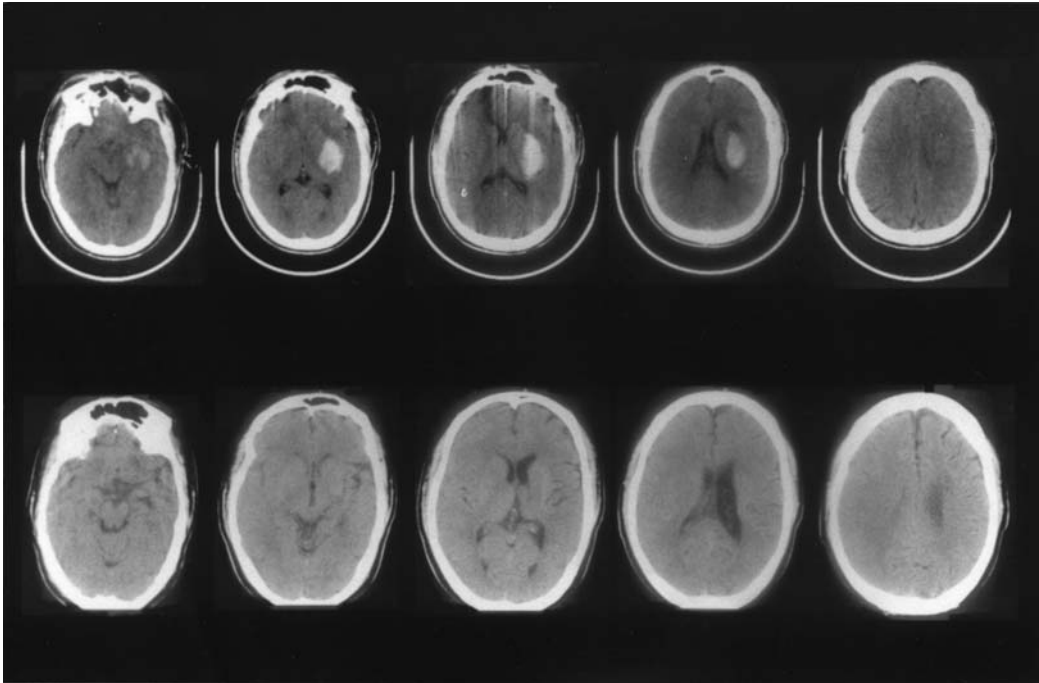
Computed tomographic scans of Pt. 5 (with global aphasia) who had poor performance on the Spontaneous Writing of Story, and of Words on the initial examination, with left putaminal hemorrhage. Top: CT scan slices where hemorrhage was present at 1 day poststroke; the hemorrhage involved putamen with superior extension into the corona radiata, lateral to the body of the lateral ventricle. Note, this case who had poor performance on Spontaneous Writing also had hemorrhage which extended into the superior white matter, lateral to the body of the lateral ventricle. Bottom: CT scan slices obtained at 50 months poststroke.
